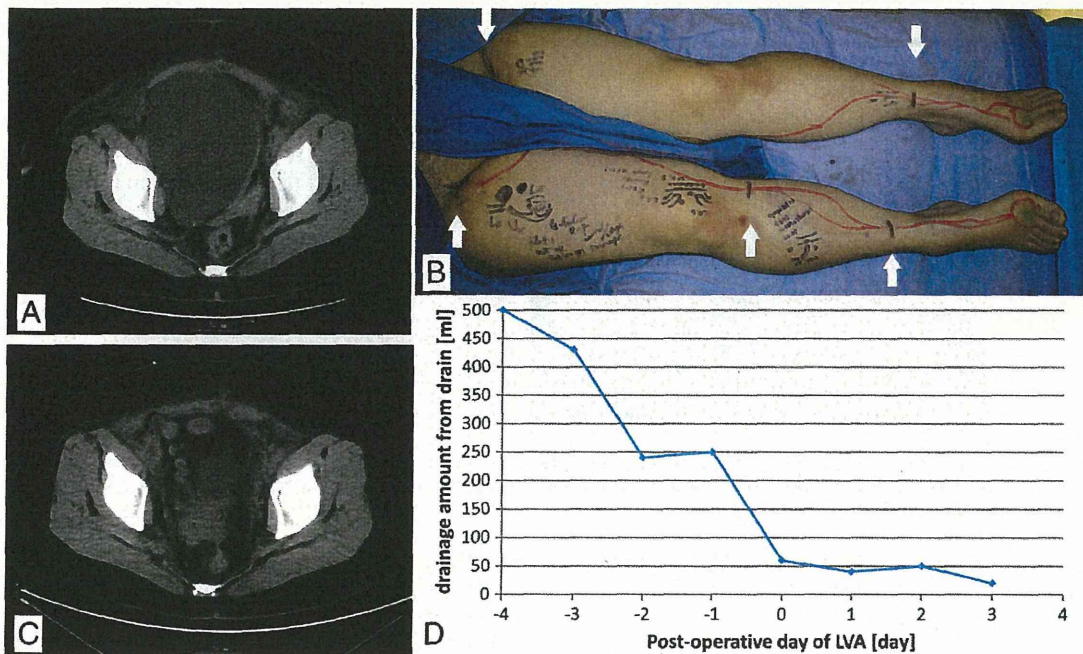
Resolution of pelvic lymphocele after LVA. (A) CT scan of a large pelvic lymphocele after gynecologic surgery. (B) Immediate postoperative view. Seven anastomoses were performed through five 3-cm incisions under local anesthesia. (C) A CT scan of the same patient 3 days after LVA demonstrates complete resolution of the lymphocele. (D) The drainage chart of the same patient demonstrates large daily drainage volumes before LVA. Following LVA, the volume of fluid drained was dramatically reduced, and the drain was removed on postoperative day 4.
